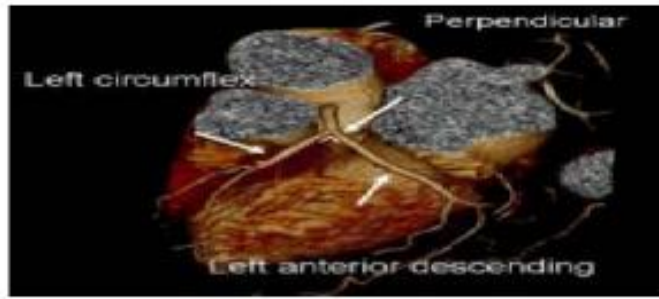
LCA branches on 3D CT visualization image [6].
